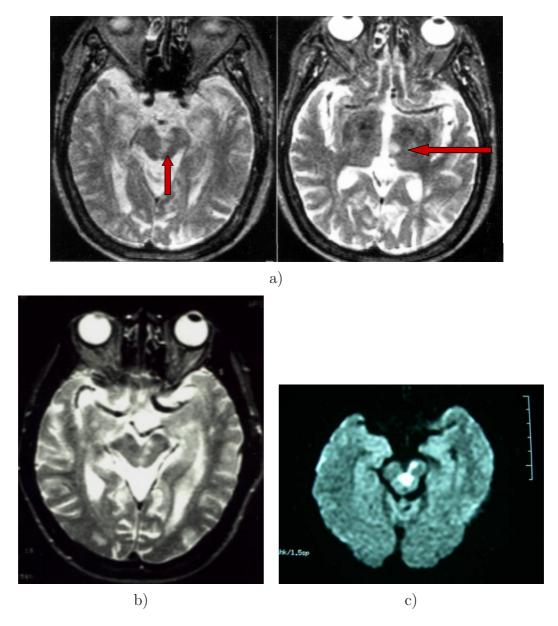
Magnetic resonance images show unilateral acute infarctions of the paramedian midbrain and medial thalamus in a patient with paramedian mesencephalic artery syndrome (T2-weighted image) (A). T2WI (B) and Diffusion weighted image (DWI) (C) of another case shows an infarction involving the paramedian midbrain and left cerebral peduncle.
